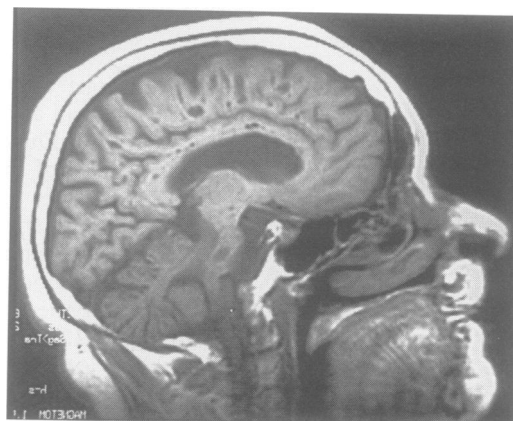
(patient 1) Several lacunes <10 mm diameter all along the corpus callosum but also within the ovale centrum on sagittal T1 weighted MRI.
